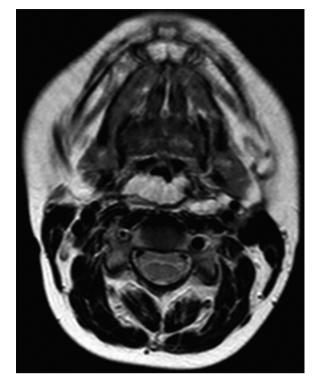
Patient #2, preoperative MRI T2 sequence, showing a remnant of a retropharyngeal lymphatic malformation.
